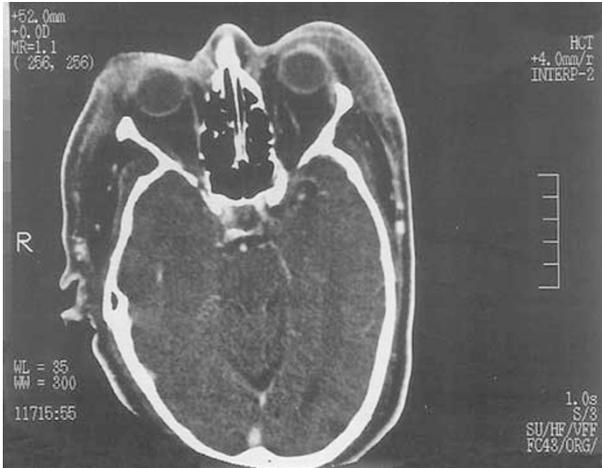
CT demonstrates preseptal and facial swelling.
